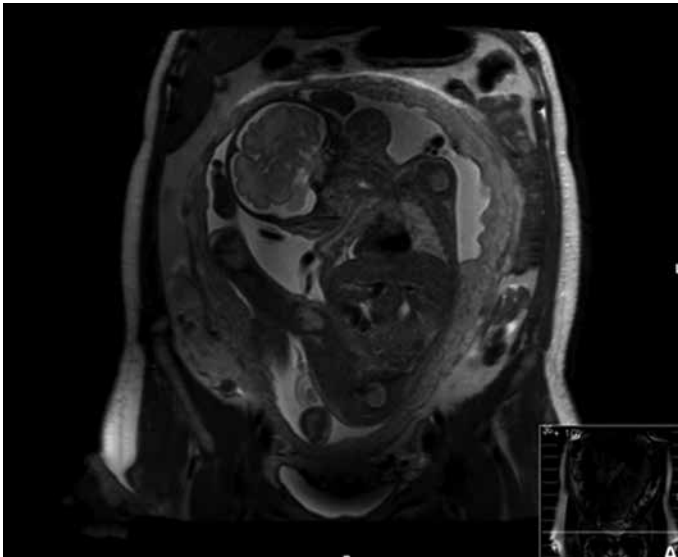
Fetal MRI image at 30 weeks and five days
